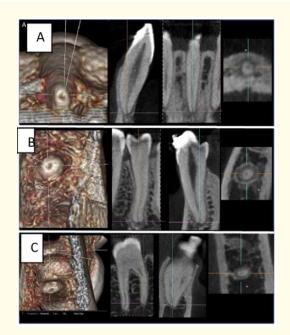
[9] 3D reconstruction of a cone-beam examination of the apical region showing the situation of the apical foramina: A: Lower central incisor. B: Lower first premolars. C: 1st lower molar.
